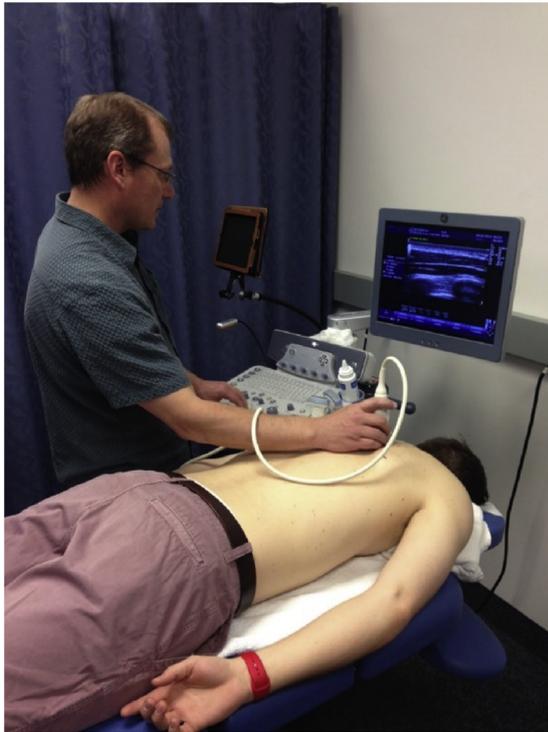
Subject positioning during ultrasound data collection. The subject in prone position, shoulder slightly retracted by bolster.
